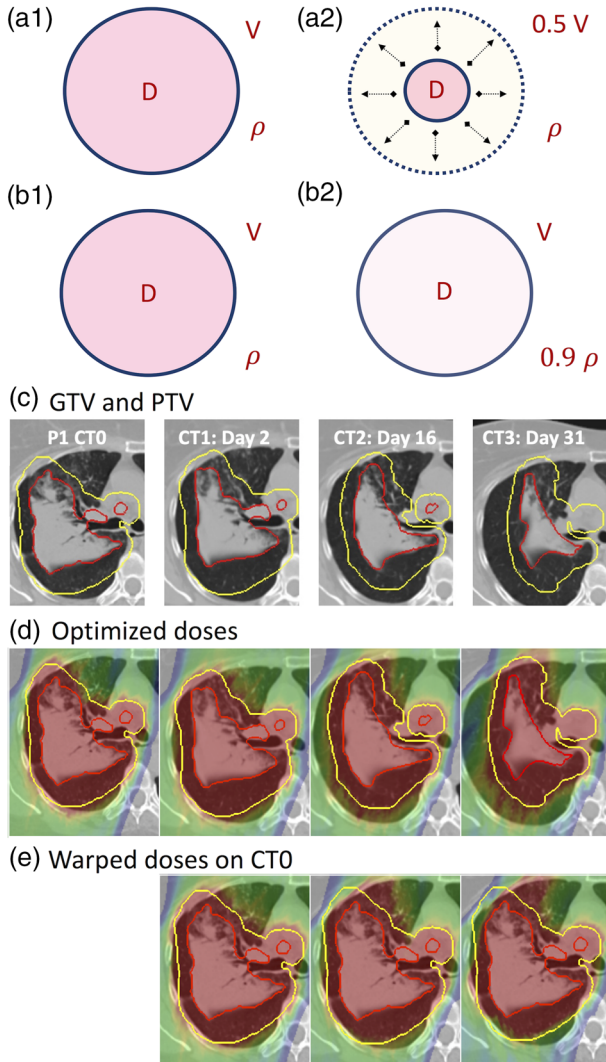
(a) Ideal model for ROI volume variation. (b) Ideal model for ROI density variation. (c) GTV (red) and PTV (yellow) variations in Patient 1 from planning day to treatment day 31. Similar variations were observed for the other patients and are shown in the supplement. (d) Optimized IMPT Gantry treatment plans for the respective CTs. (e) Warped doses on planning CT
